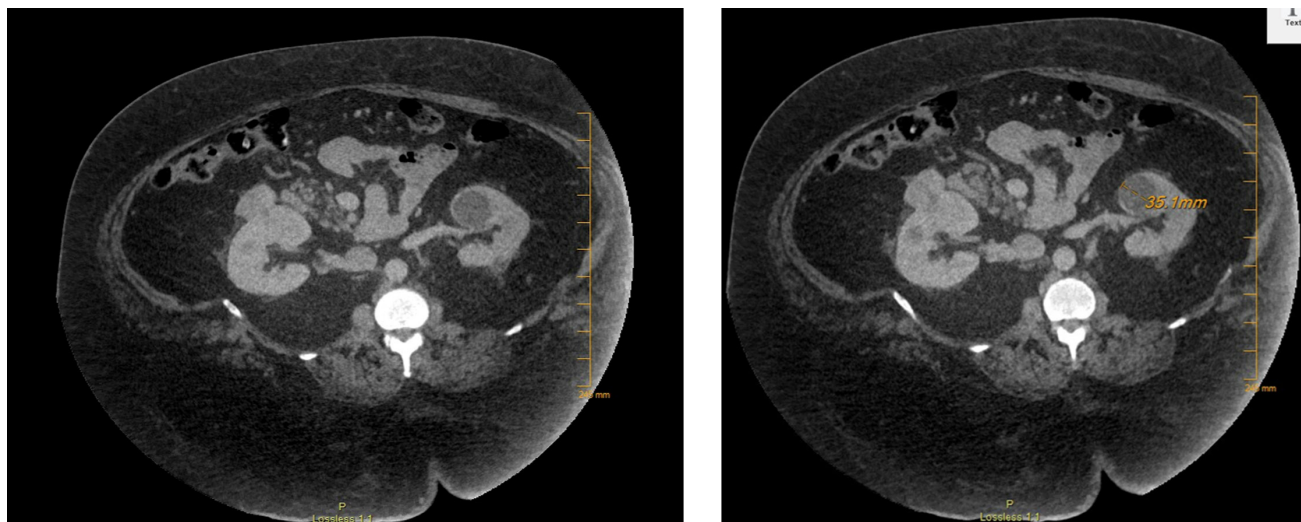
CT abdomen and pelvis with contrast showing Right Renal Cell Carcinoma.
